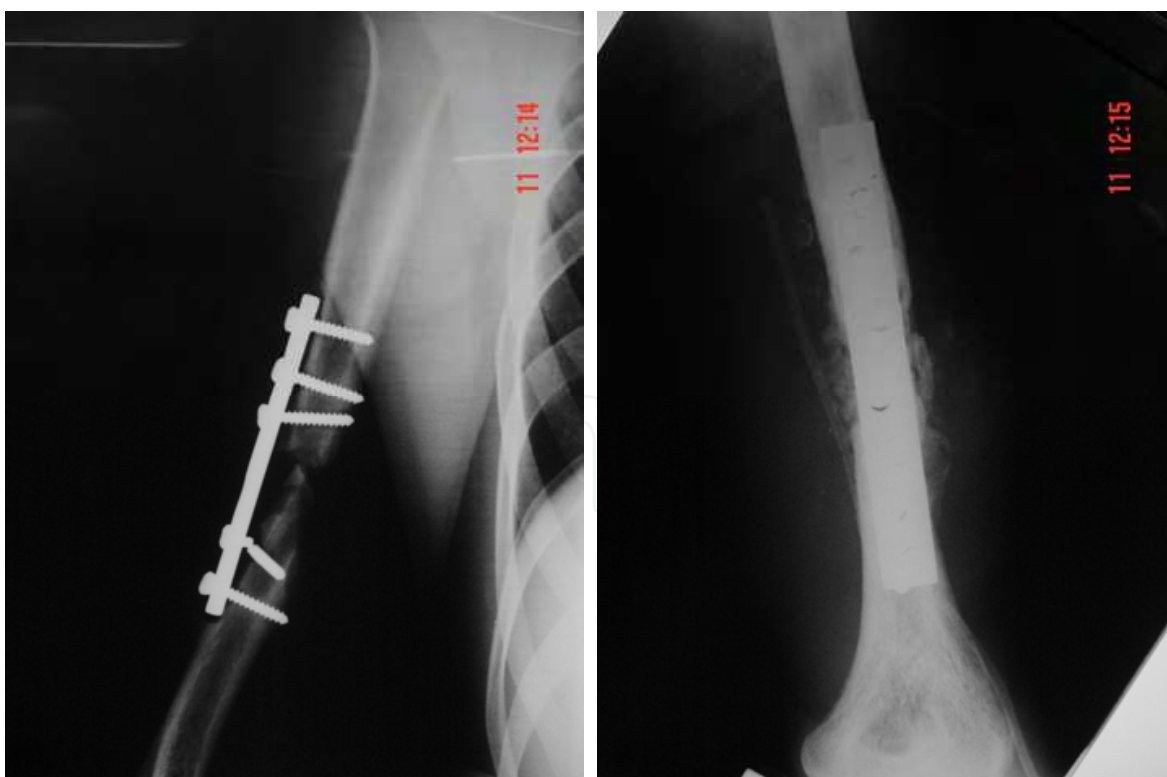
Radiograph showing a nonunion of the humerus with a partial bone defect (left), treated with resection of the edges, bone shortening of 3 cm, and change of the synthesis material associated with bone grafting.
